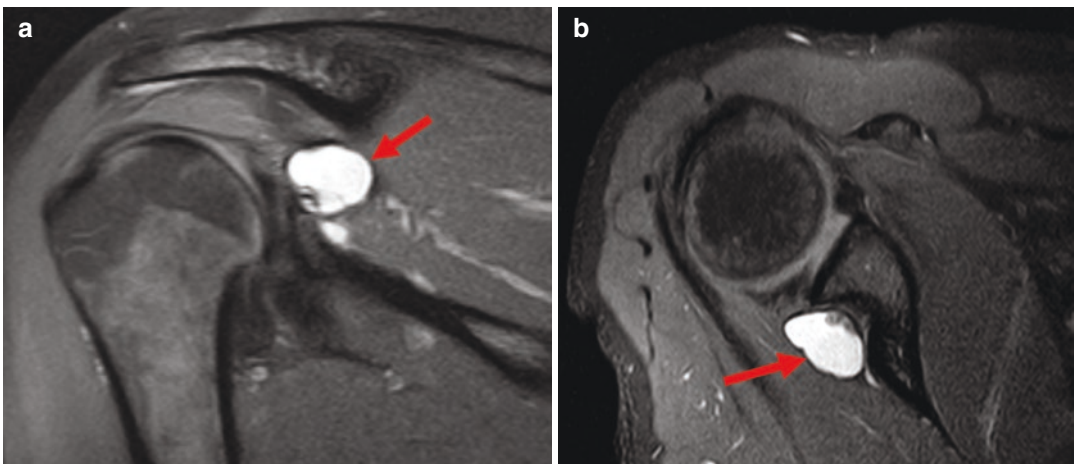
MRI of a right shoulder showing a spinoglenoid notch ganglion cyst (arrow). (a) Coronal view, PD-weighted sequence. (b) Axial view, PD-weighted sequence
